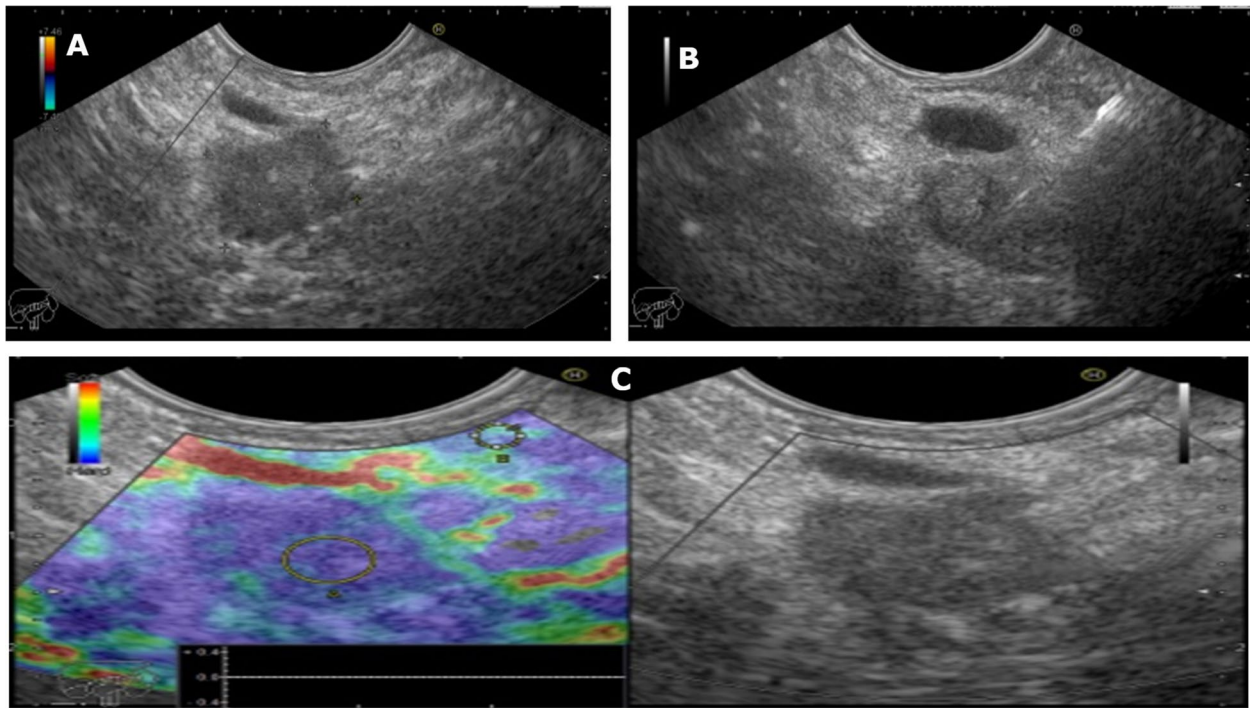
Endoscopic ultrasound pictures showing ampullary hypoechoic lesion (A). EUS-guided fine needle aspiration was done with a final diagnosis of ampullary adenocarcinoma. C Heterogenous blue green color by elastography denoting the increased hard stiffness of the lesion
